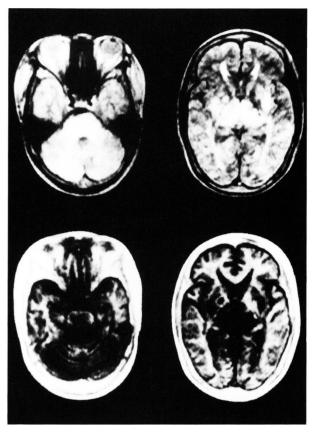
T2-weighed MRI performed on the day of admission showed high intensity areas in right temporal lobe, brain stem, left cerebellum, bilateral thalamus and basal ganglia. T1-weighted images (IR) demonstrated abnormal areas as low intensity areas. Scanning was performed with the same condition as case 1.
